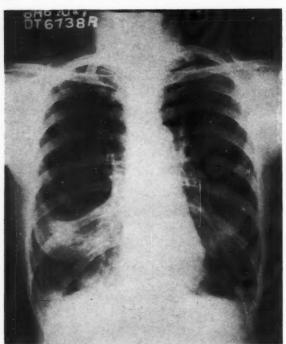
Case III. X-ray of the chest.
